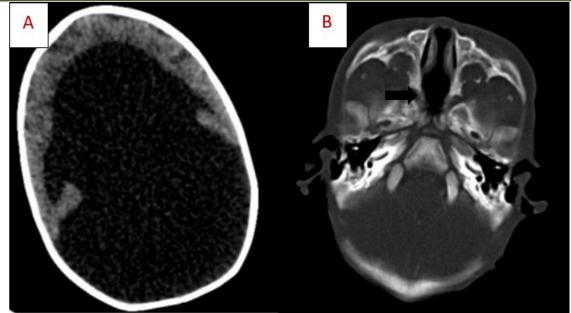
A: Axial CT images showing a single large U-shaped ventricular cavity, fused thalamus with a thin rim of peripheral cerebral parenchyma and an absence of the interhemispheric fissure. B: A single nostril and choanal atresia (black arrow)
